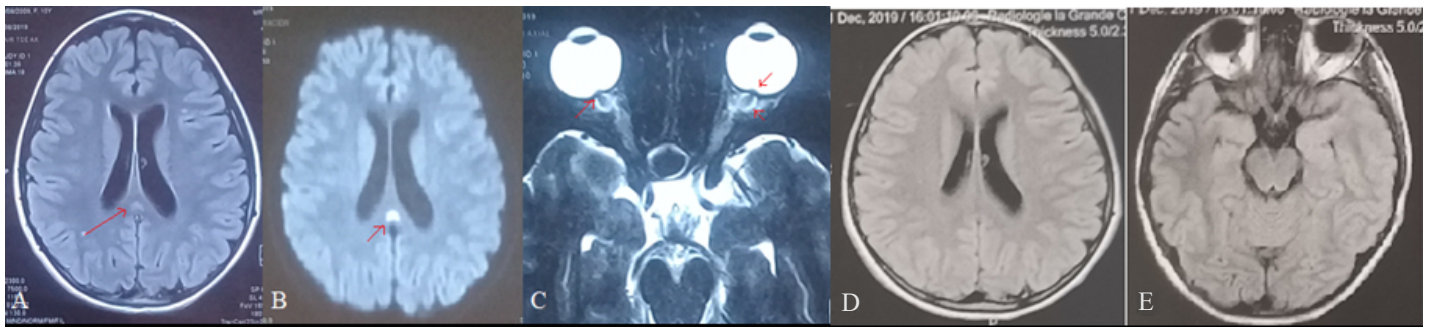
Brain magnetic resonance imaging at diagnosis and 6 months follow-up. (A) FLAIR sequence: 9 mm nodular hypersignal of the splenium of the corpus callosum (arrow). (B) Diffusion-weighted imaging (DWI): hyperintense signal (arrow). (C) T2 thin section sequence through the optic nerves showing the indirect signs of idiopathic intracranial hypertension: protrusion of the optic nerve papilla, tortuosity of the optic nerves with dilatation of their sheaths, and flattening of the posterior pole of the eyeball (arrows). (D), (E) 6-month follow-up brain MRI shows complete regression of the splenium lesion of the corpus callosum, as well as the indirect signs of idiopathic intracranial hypertension.
